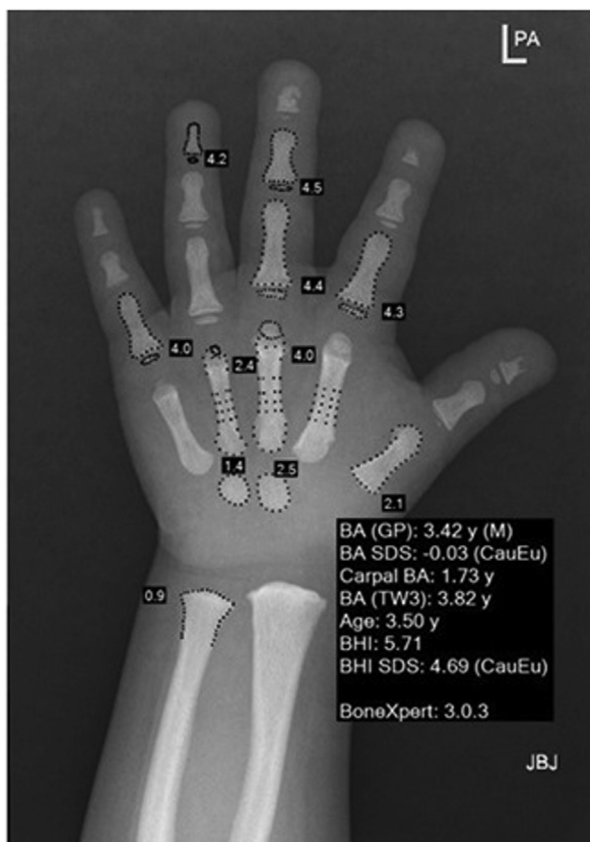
Bone age x-ray at the age of 3.5 years showing congruent bone age (Greulich & Pyle bone age 3.42 years, -0.03 SDS) and very dense osteosclerotic bones with acroosteolysis affecting the third and fourth terminal phalanges, characteristic of pycnodysostosis. SDS = standard deviation score.
